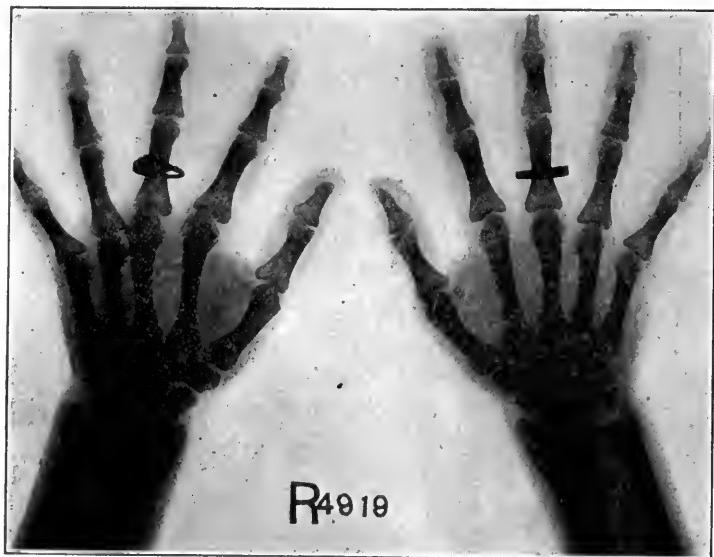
Roentgenograph of the hand of T. T. at 22 years of age
